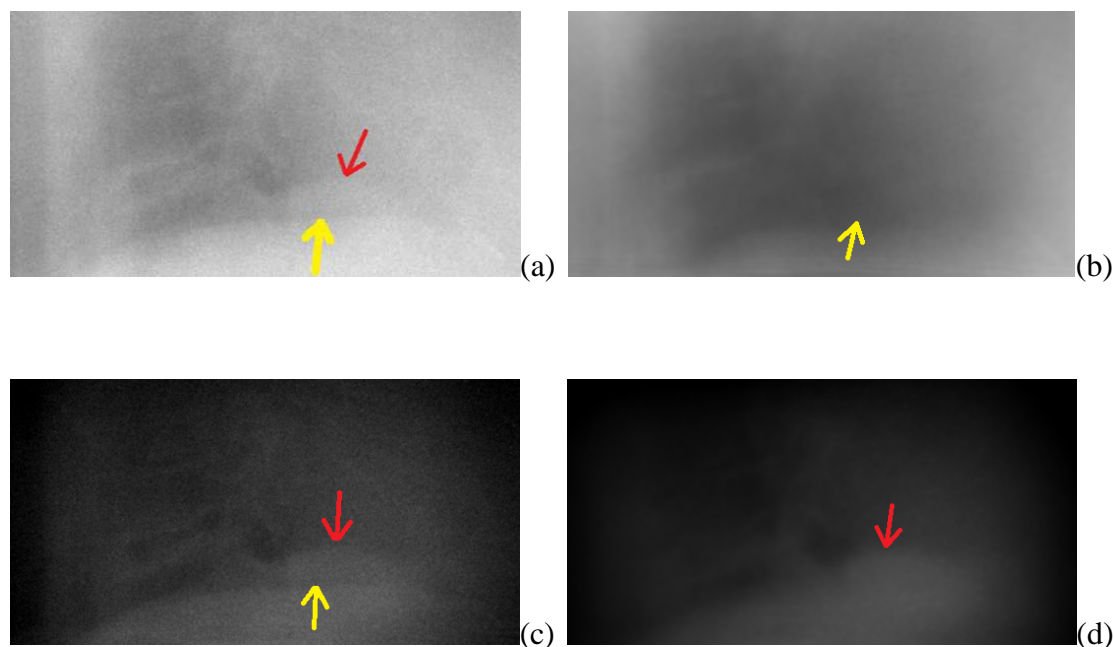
One frame of OOI enhanced beam attenuation image of patient under 10MU MVCBCT scan. (a) The original image; (b) projected image of non-OOI (background) region; (c) subtracted image; (d) projected image of OOI region. All the images are displayed using the same level and window. The red arrows points to the desired hemidiaphragm. The yellow arrow points to CLHD. Note how the gradient becomes relatively stronger than the CLHD in the enhanced images.
